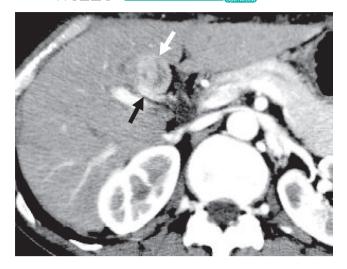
CT at the time of the initial surgery. A round tumor (white arrow) approximately 2 cm in diameter was in contact with the root of the right hepatic duct (black arrow). CT, computed tomography
